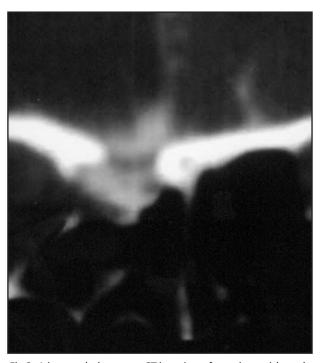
A intratechal contrast CT imaging of a patient with a ethmoid roof fracture.
